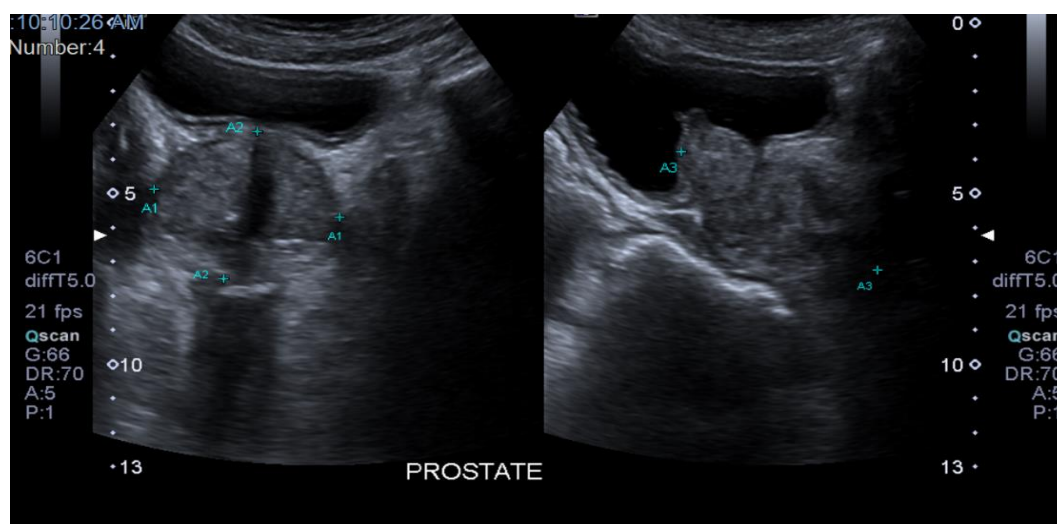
Ultrasound of prostate showing enlarged gland with heterogeneous texture.
